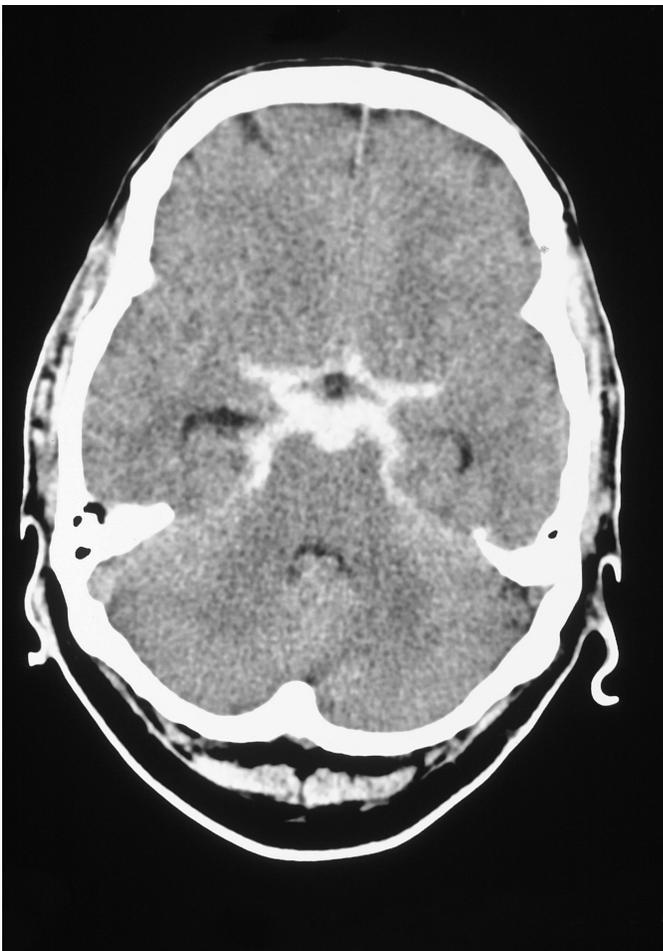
Nonaneurysmal perimesencephalic hemorrhage. CT scan of the brain of a 60-year-old woman, within 24 hours after the sudden onset (within seconds) of an unusually severe headache. There is dense subarachnoid blood in the interpeduncular cistern, ambient cisterns, and chiasmatic cisterns, but not at all in the Sylvian fissures or in the frontal interhemispheric fissure (also not on other slices). This pattern of hemorrhage is unusual for an arterial (aneurysmal) hemorrhage and fairly characteristic for a nonaneurysmal perimesencephalic hemorrhage. The CT angiogram was completely normal, also in the posterior circulation. The patient completely recovered and resumed her usual lifestyle
